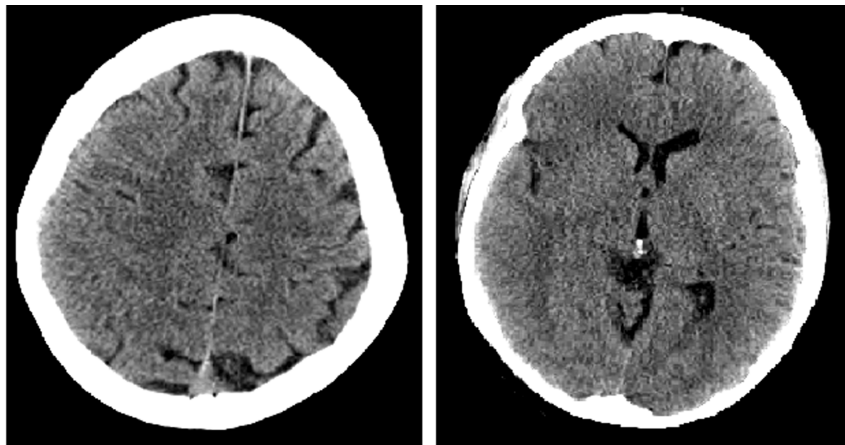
Example of ASPECTS 5 on NCCT
